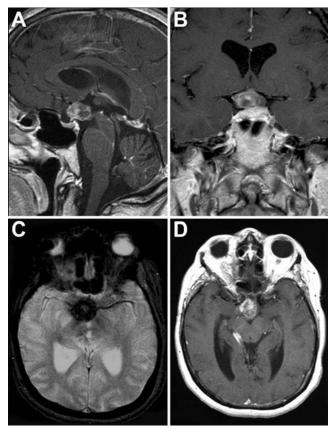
Preoperative sagittal (A), coronal (B), and axial (D) post-Gd T1-weighted and axial gradient-echo (C) MR images demonstrating a heterogeneously enhancing suprasellar CM of the optic chiasm. Because the lesion was located within the third ventricle, a translamina terminalis approach was required to remove the lesion. Gradient-echo sequence (C) showing blooming consistent with hemosiderin deposition. There is an associated venous angioma located in the right posterolateral mesencephalon (D).
